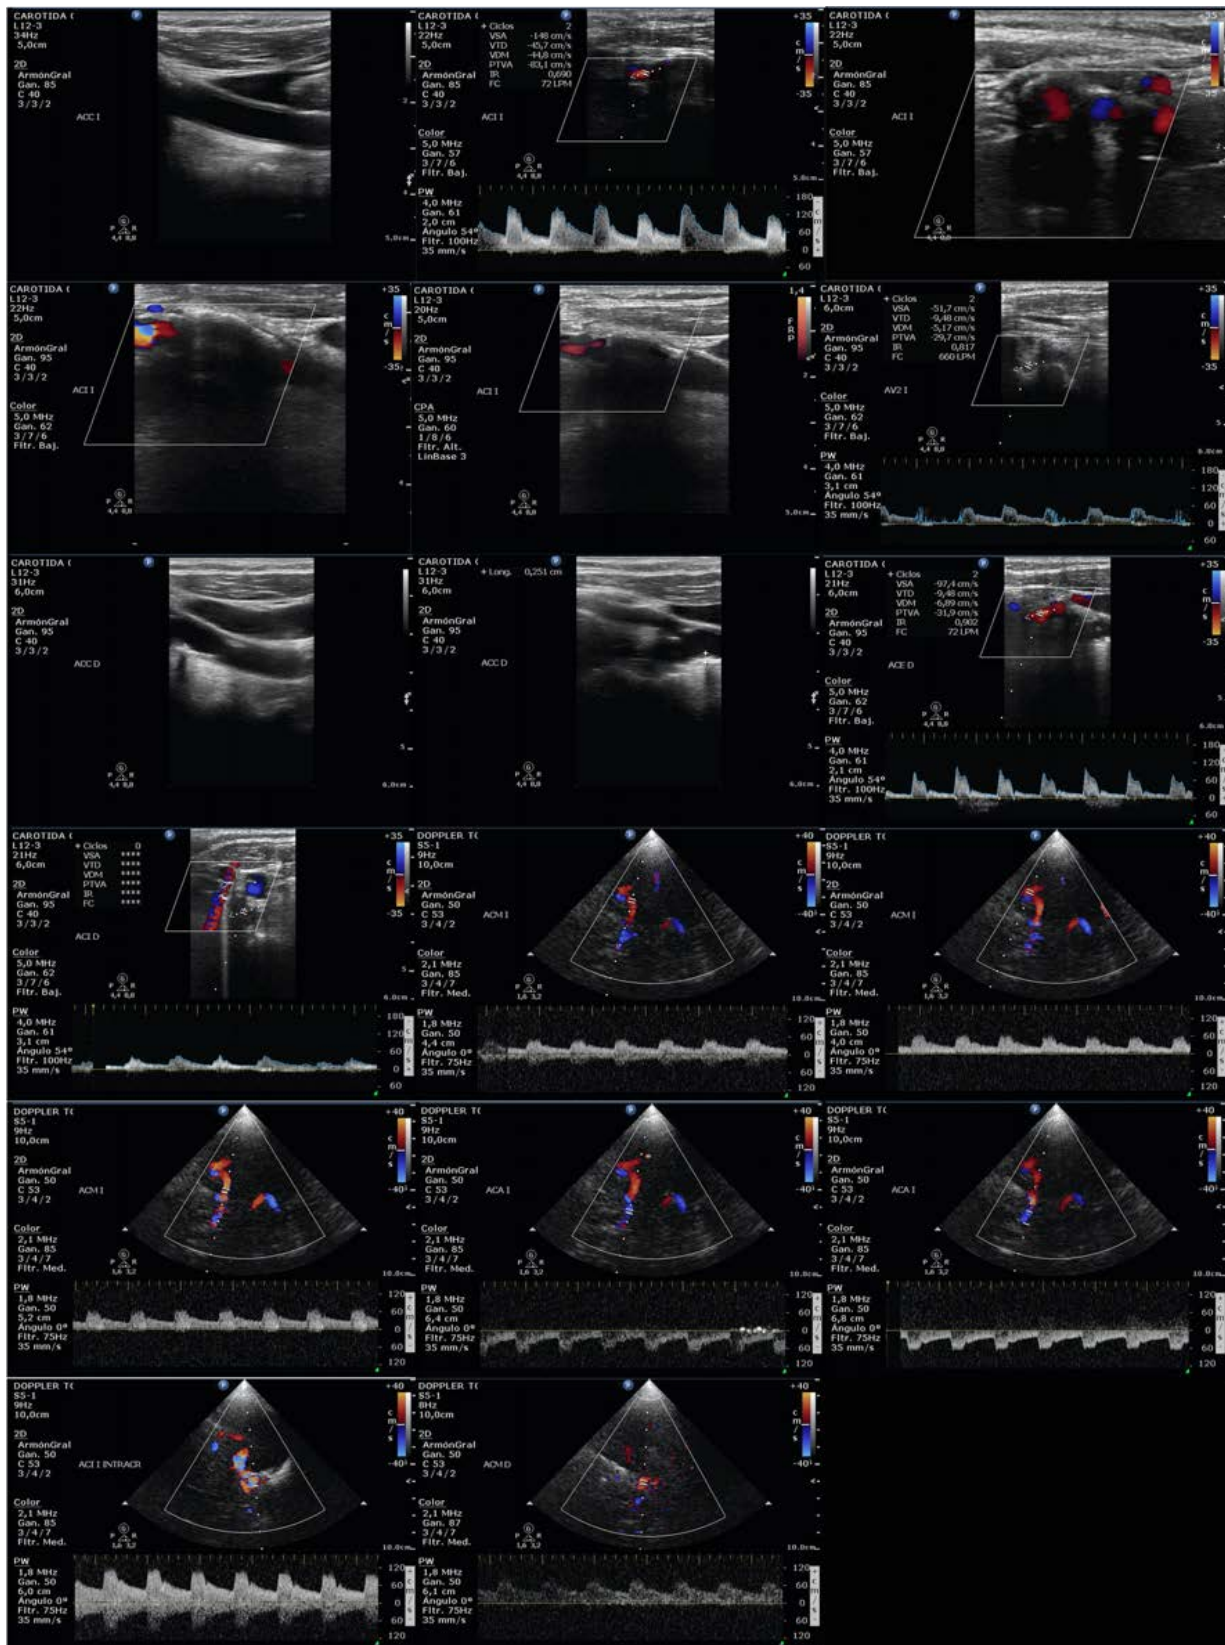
Point-of-care cervical and transcranial doppler ultrasound showing significant stenosis in the right and left internal carotid arteries
